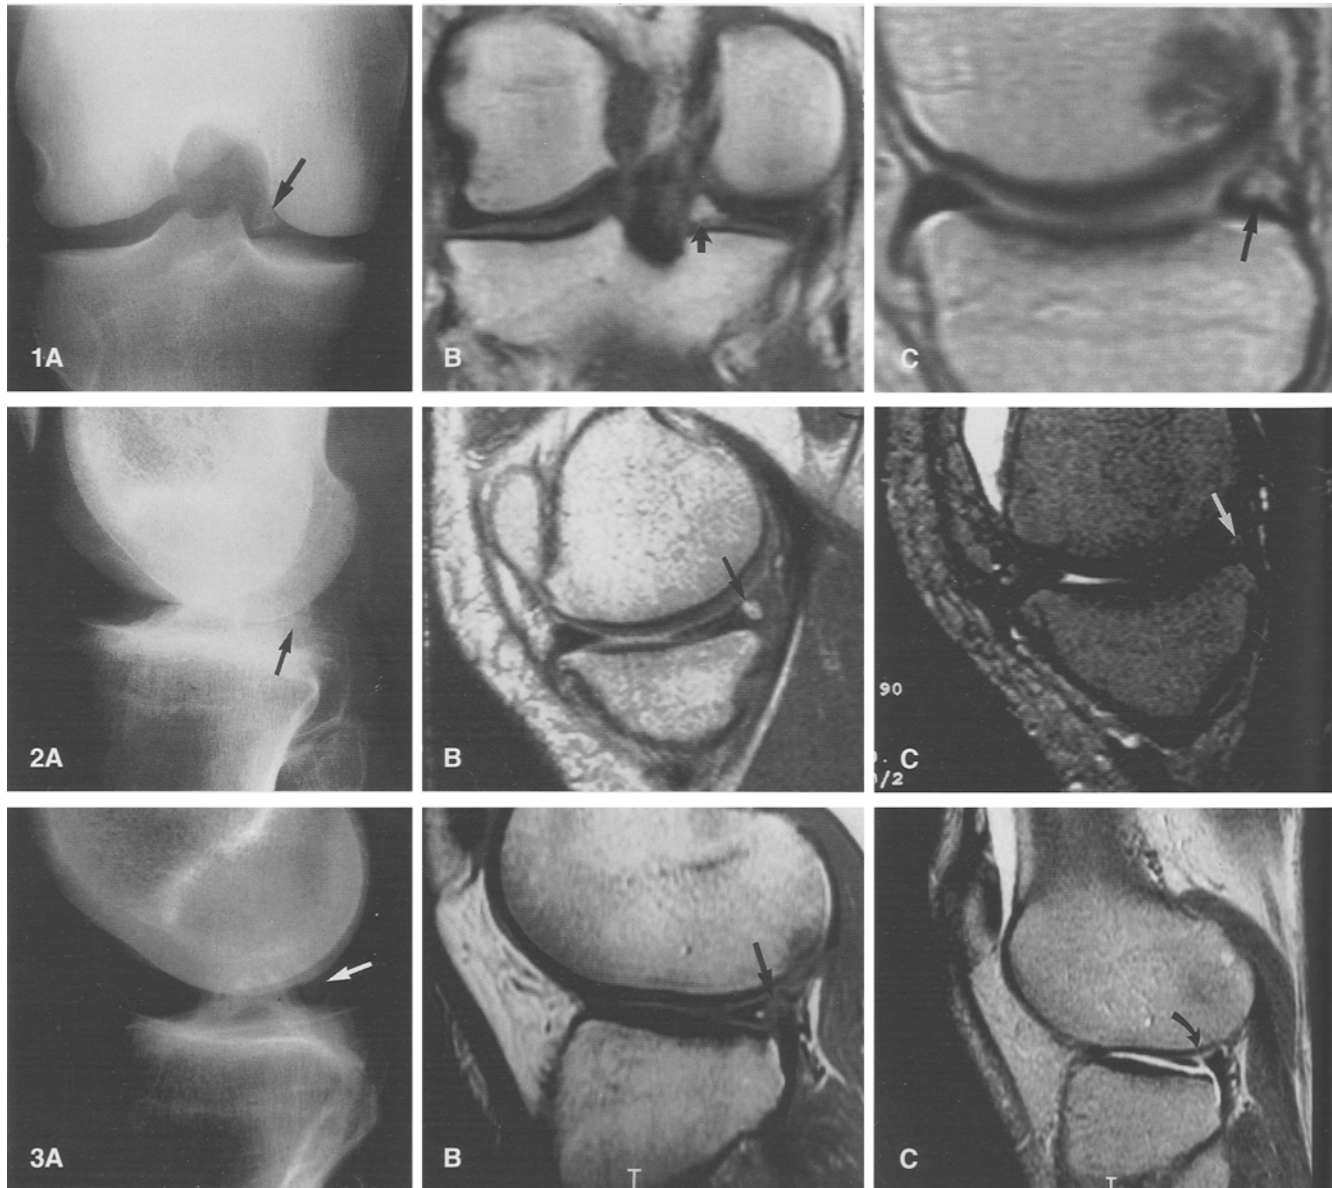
A–C. A 56-year-old man with intermittent knee pain. A Frontal knee radiograph demonstrates an ossific density projected in the medial aspect of the joint (*arrow*). B, C Coronal and sagittal T1-weighted (TR600/TE20 ms) MR images demonstrate that the ossicle is surrounded by the fibrocartilage of the posterior horn of the medial meniscus (*arrows*)
